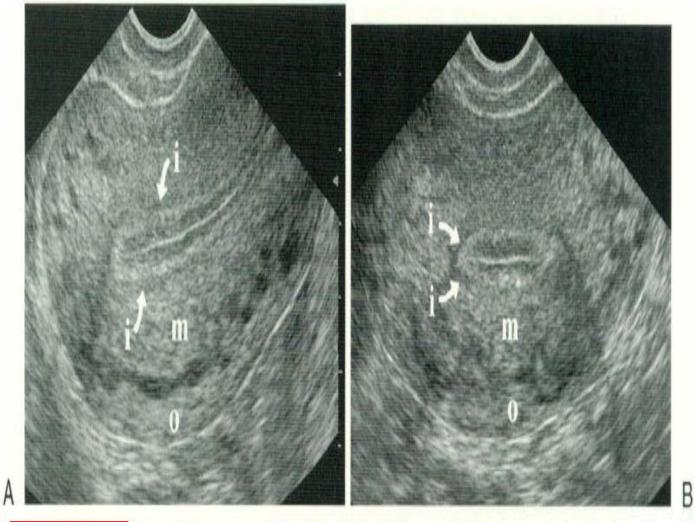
Myometrial layers. Transvaginal sonogram in the (A) sagittal and (B) coronal planes demonstrating the inner (i), middle (m), and outer (o) layers of myometrium.
